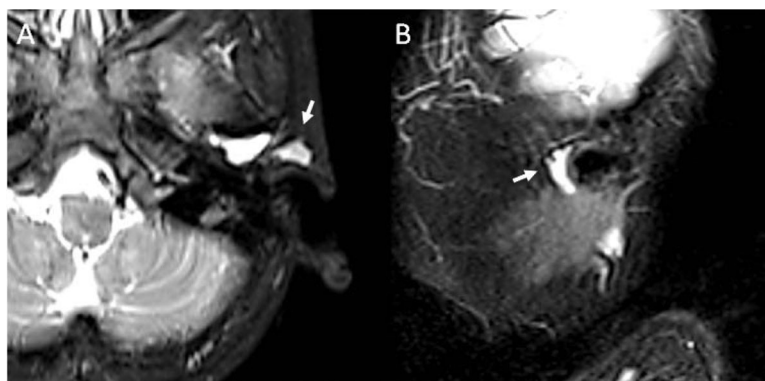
Axial (A) and sagittal (B) fat-suppressed T2-weighted MR images of a child with a Work type I first branchial cleft anomaly. The images demonstrate a cystic structure in the left pinna region anterior to the external auditory canal. The sinus tract runs parallel to the external auditory canal.
